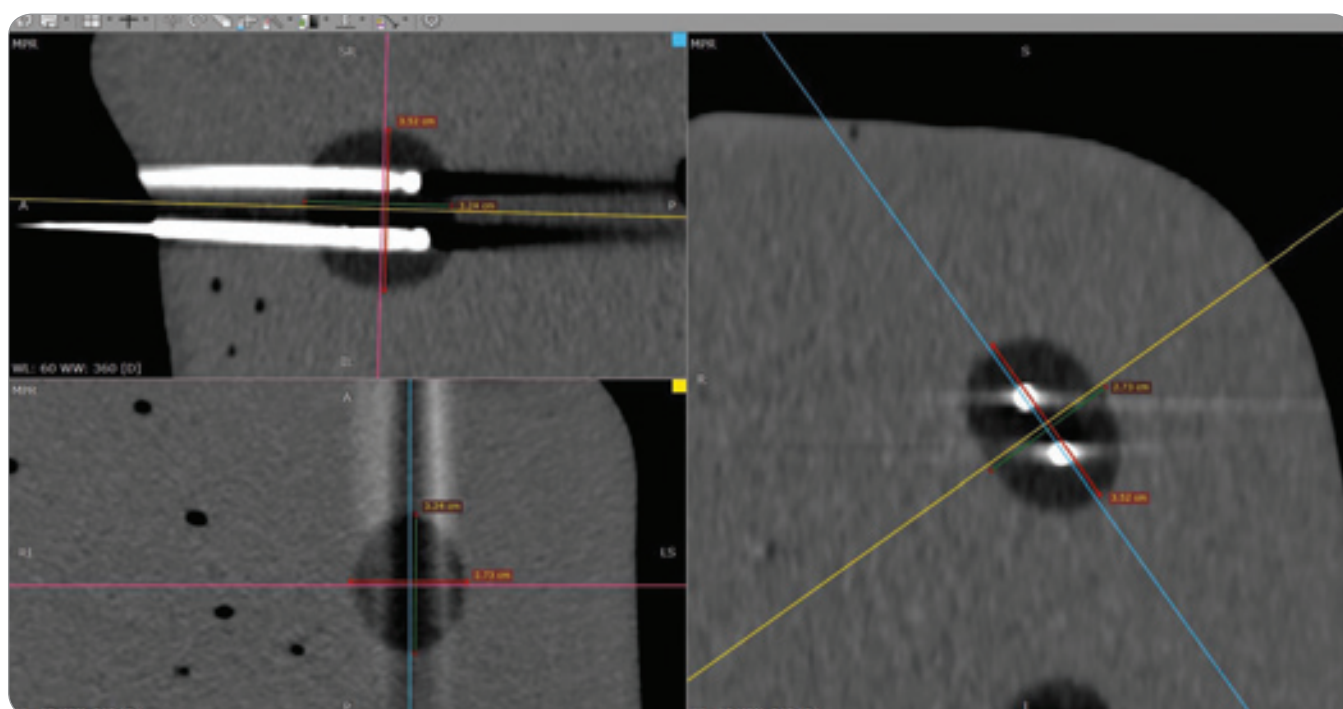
CT scan of the ice ball created using the double IceSphere™ needle configuration after a 10-minute freezing cycle at 20% intensity.
